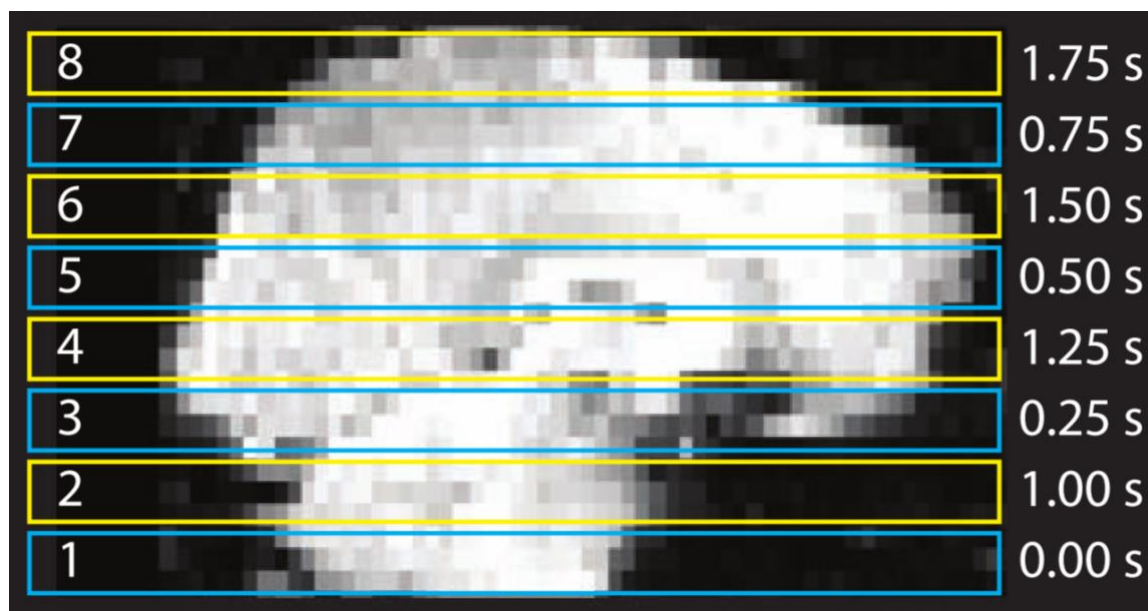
An example of slice timing in an interleaved MRI acquisition; taken from [219]
